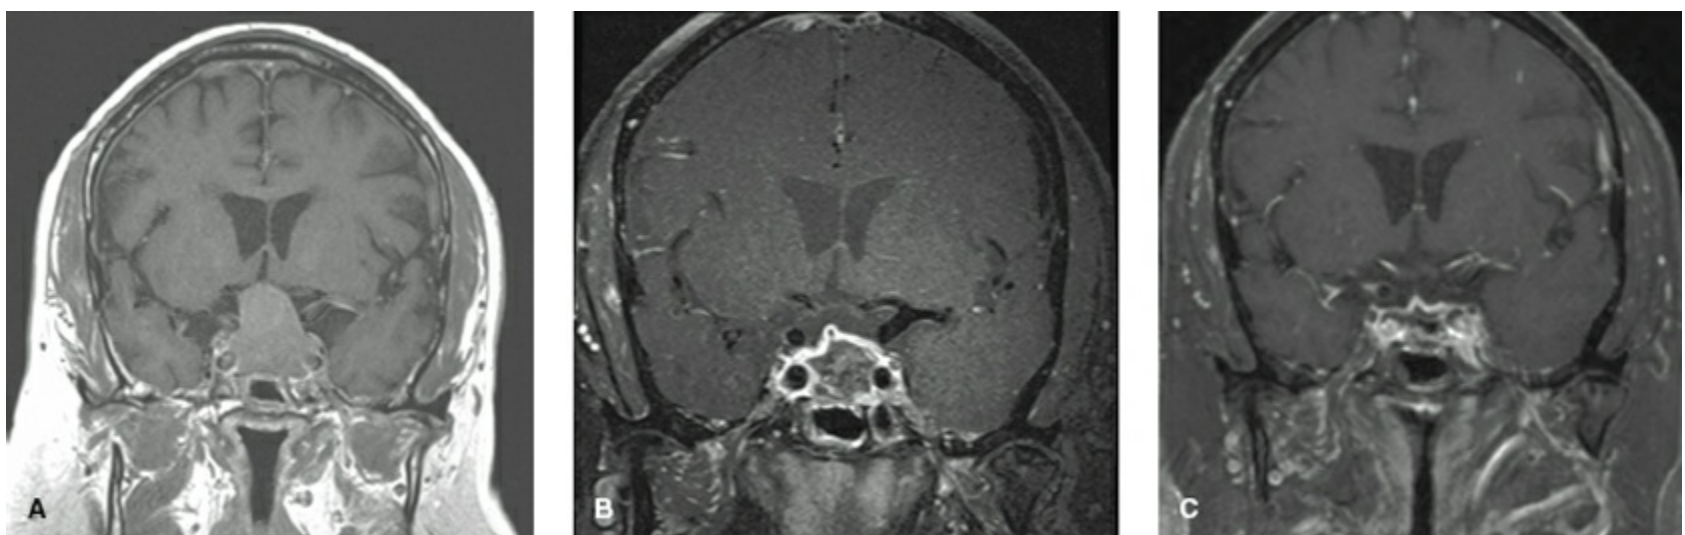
A: The coronal view (T1-weighted image with contrast) of a large nonfunctioning macroadenoma with significant chiasm compression. B: The intraoperative MRI (T1-weighted image with contrast) shows tumor removal with fat packing and hemostatic material in place. The chiasm is decompressed. C: The postoperative MRI at 8 weeks shows partial resorption of the fat packing and hemostatic material.
